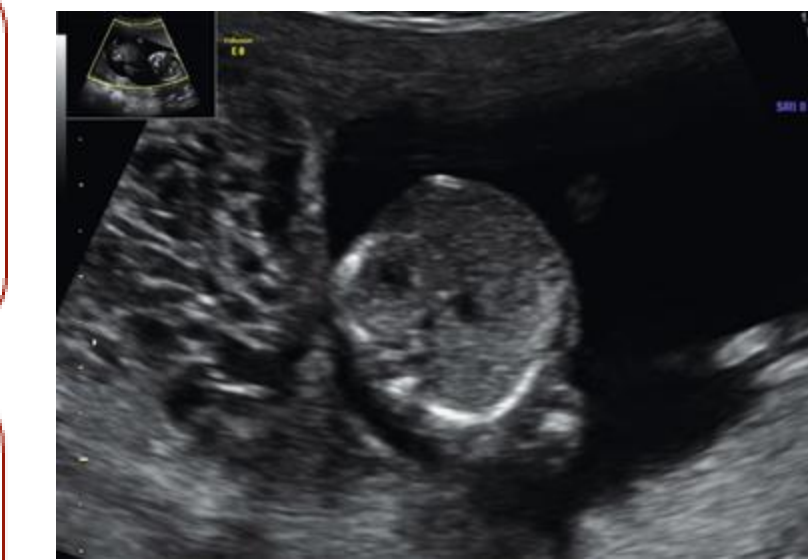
Ultrasound depicting a CMCF pregnancy. Molar tissue is seen on the left and the fetal abdomen is seen on the right. This image was taken from a previous case report of a CMCF pregnancy in a 33 year-old at 14 weeks gestation.<sup>2</sup>
